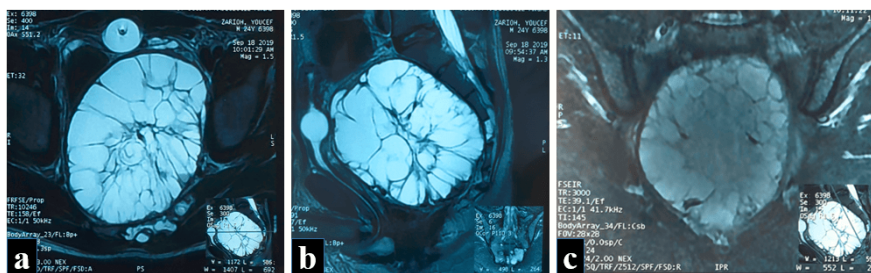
MR images demonstrating a giant multicystic lesion developed in the pre-sacral space. The lesion had a clear multilocular fluid content with a high signal in T2-weighted with an attenuated high signal in FAT saturation sequences, delimited by thin septa and well circumscribed by a wall in low signal T2. Calcification-related signal voids were identified in all MRI sequences. No solid component is identified and no contrast enhancement has been demonstrated. A massive portion of the mass falls into the pre-sacral space pushing the rectum and bladder forward. (a) Axial T2-weighted image. (b) Sagittal T2-weighted image. (c) Coronal fat saturation-weighted image.
